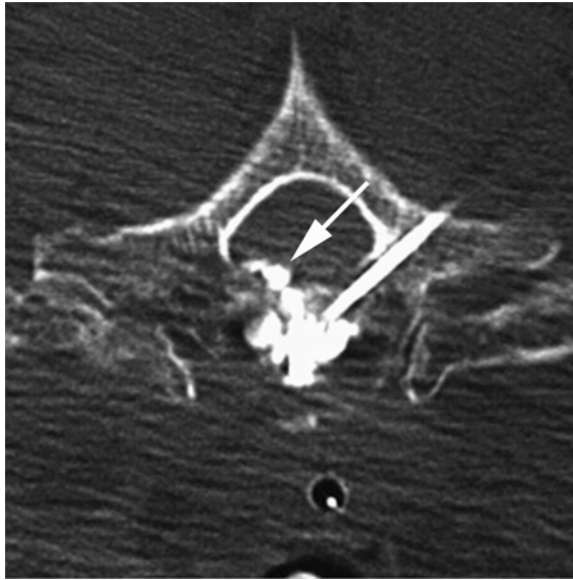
A CT image taken during PV showing cement filling of a T1 vertebra (invaded by tumor) with a small (asymptomatic) cement leak into the spinal canal (white arrow). Cement injection was terminated, and the patient had a good result from the PV.
